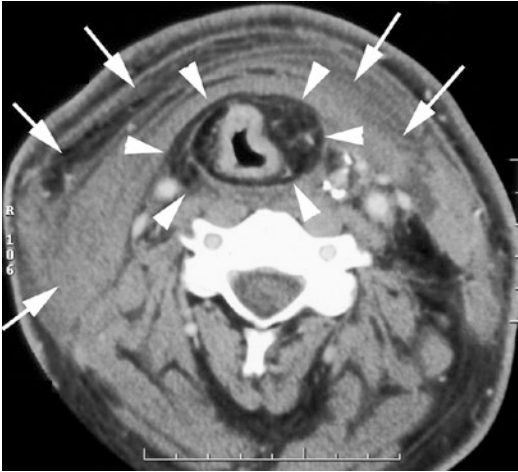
Axial contrast-enhanced CT image, in a patient treated by total laryngectomy. The neopharynx is reconstructed by a free radial forearm flap (arrowheads; inner enhancing rim is skin); the soft tissues are anteriorly covered by a pedicled pectoralis major flap (arrows)
